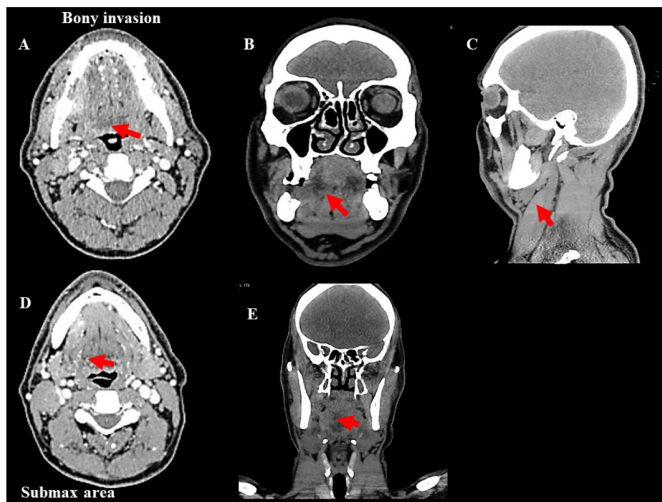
Selected views of Gadolinium-enhanced MRI of presented case. Necrotic, hypodense lymphadenopathy lesions are presented in carotid region and right submandibular area.
